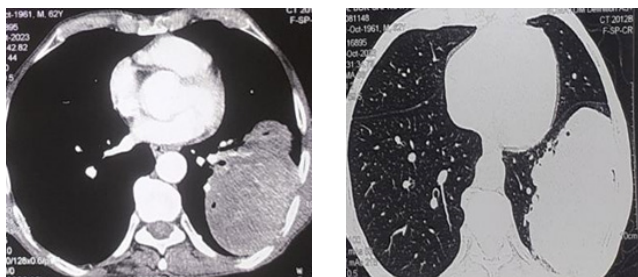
Contrast Chest CT in mediastinal and lung window show a large enhancing peripheral left lung mass.
